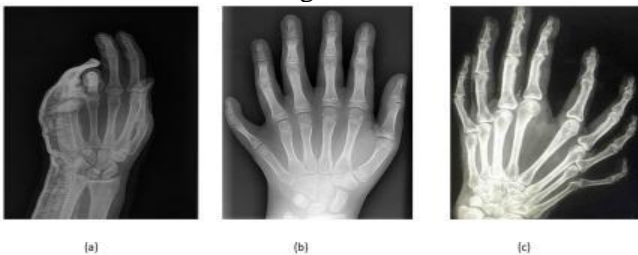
Abnormal finger count: (a) patient radiograph having syndactyly abnormality, (b) the patient having polydactyly syndrome, (c) severe polydactyly syndrome of the patient
